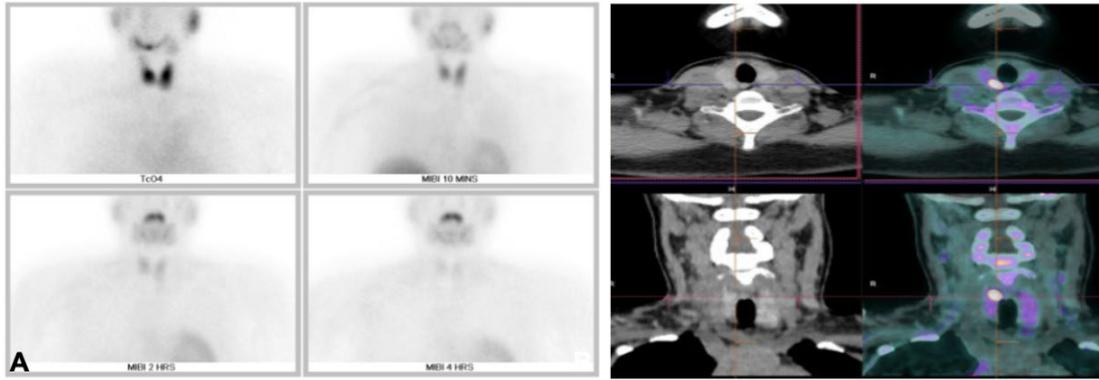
Dual tracer Tc99m-Pertechnetate and Tc99m-Sestamibi. F18-Choline PET/CT images of a 24-year-old female with high clinical suspicion of a parathyroid adenoma. (A) No sestamibi-avid focus in the dual phase dual tracer scintigraphy. (B) F18-Choline-avid lesion inferior to the right thyroid lobe raises suspicion of a parathyroid adenoma
